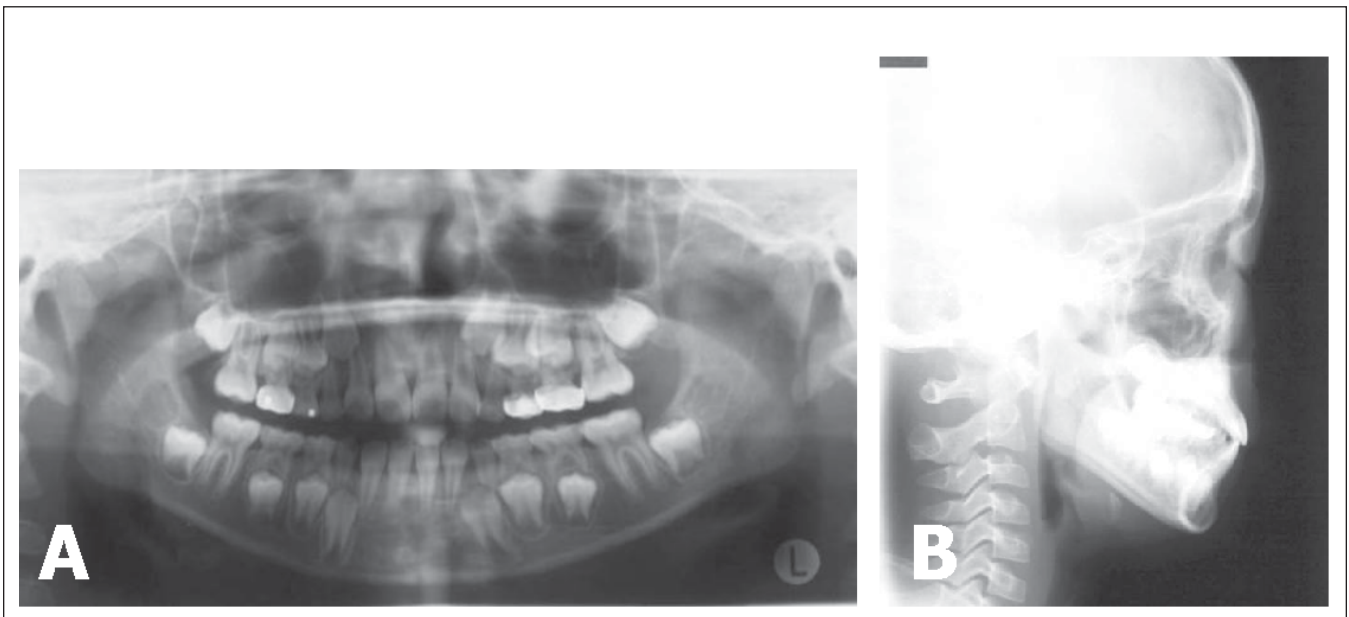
Initial radiographic views: A. Panoramic view; B. Lateral cephalometric view.
